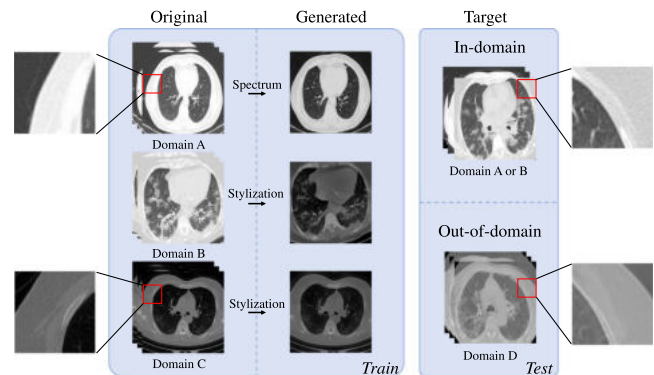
Example CT images at different domains. “In-domain” indicates the model is trained on Domains A and B, then tested on Domain A or B. “Out-of-domain” indicates the model is trained on Domains A, B and C, then tested on Domain D. The enlarged regions of the red boxes are for better visualization.
